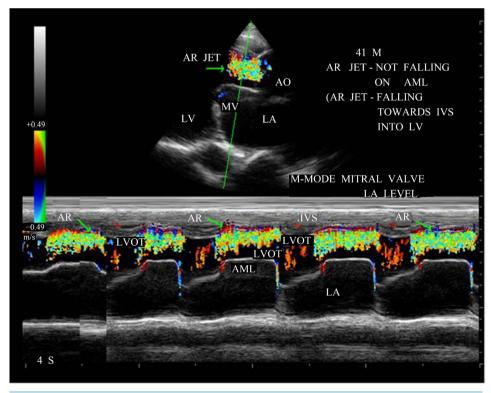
M-mode color doppler AR jet towards IVS at LA (left atrial) level.
